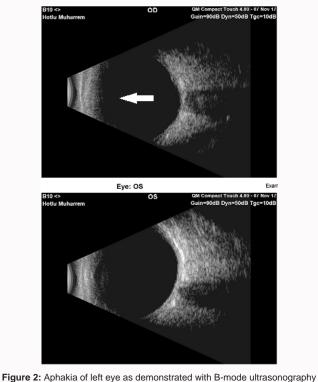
Aphakia of left eye as demonstrated with B-mode ultrasonography (arrow).
